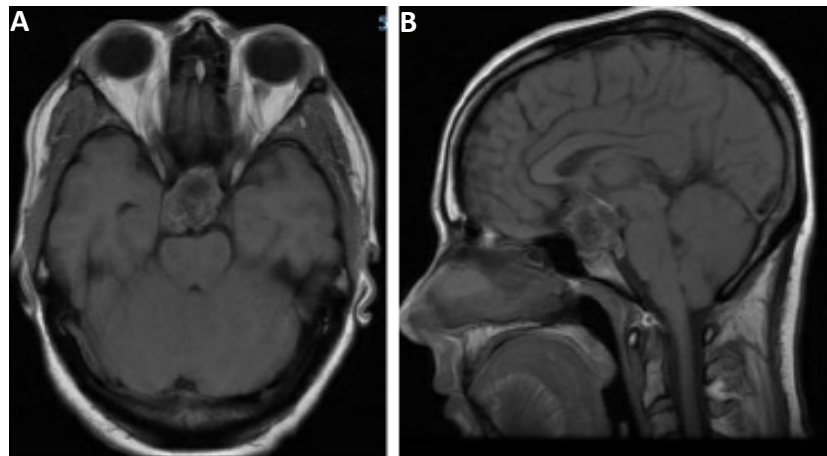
(A&B): Preoperative non contrast MRI showing the large sellar mass on axial and sagittal imaging with supra and retrosellar extension. This is a non enhancing lesion visualized here on these non contrast T1 images.
